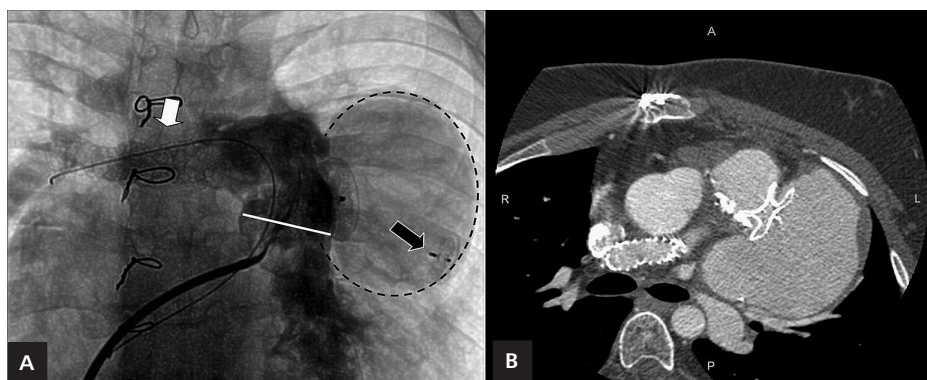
A. Angiography in the antero-posterior projection of the right ventricle after implantation of a 20 mm Amplatzer Septal Occluder; black arrow — the previously implanted Amplatzer Septal Occluder; white arrow — stents in the right pulmonary artery; white line — wide right ventricular outflow tract; black dotted line — the perimeter of the aneurysm; B. Multislice computed tomography scan after implantation of the second Amplatzer Septal Occluder to exclude the aneurysm (two stents in the right pulmonary artery also visible)
